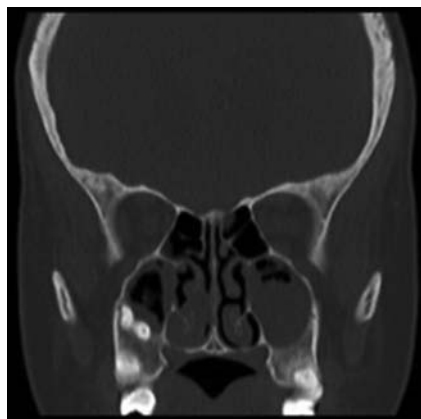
Coronal CT demonstrating acute maxillary and ethmoid rhinosinusitis with air bubbles within fluid density, indicating purulence in the right maxillary sinus
